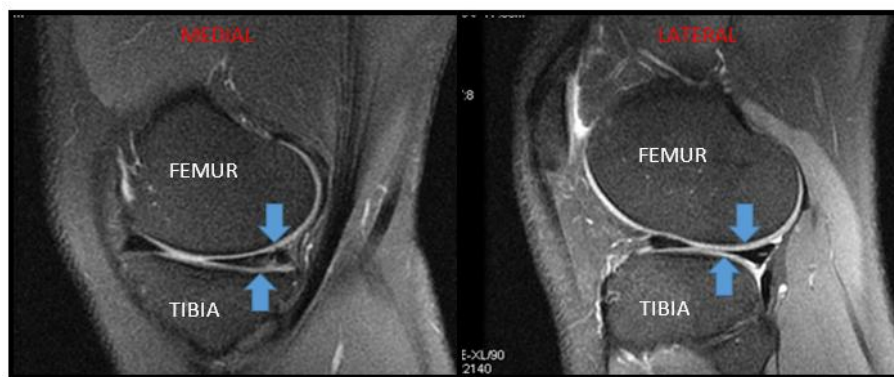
MRI Sagittal Image shows long section of medial and lateral part of femoral and tibial articular cartilage (blue arrows)
